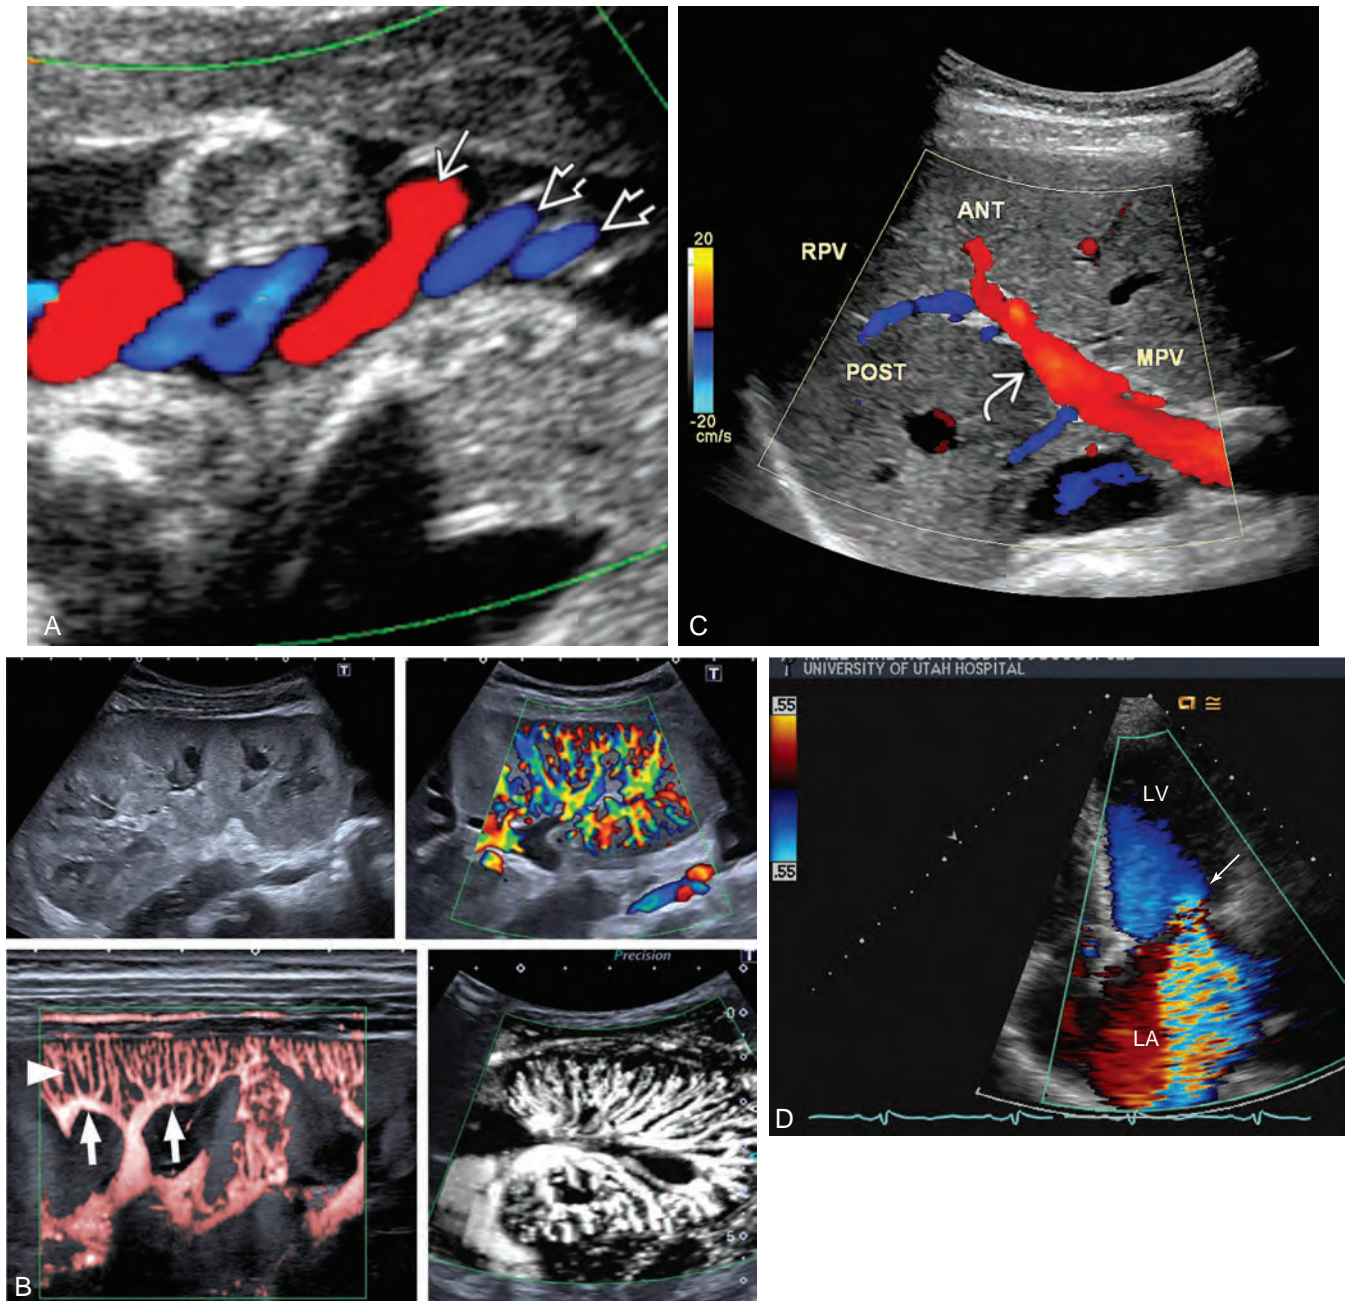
Color Doppler is sensitive to Doppler signals throughout an adjustable portion of the area of interest. A real-time image is displayed with both gray scale and color flow in the vascular structures. Color Doppler is able to analyze the phase information, frequency, and amplitude of returning echoes. (A) Normal three-vessel umbilical cord. (B) Normal renal vasculature. (C) Normal portal vein flow. (D) Abnormal flow from the mitral regurgitation into the left atrial cavity.
